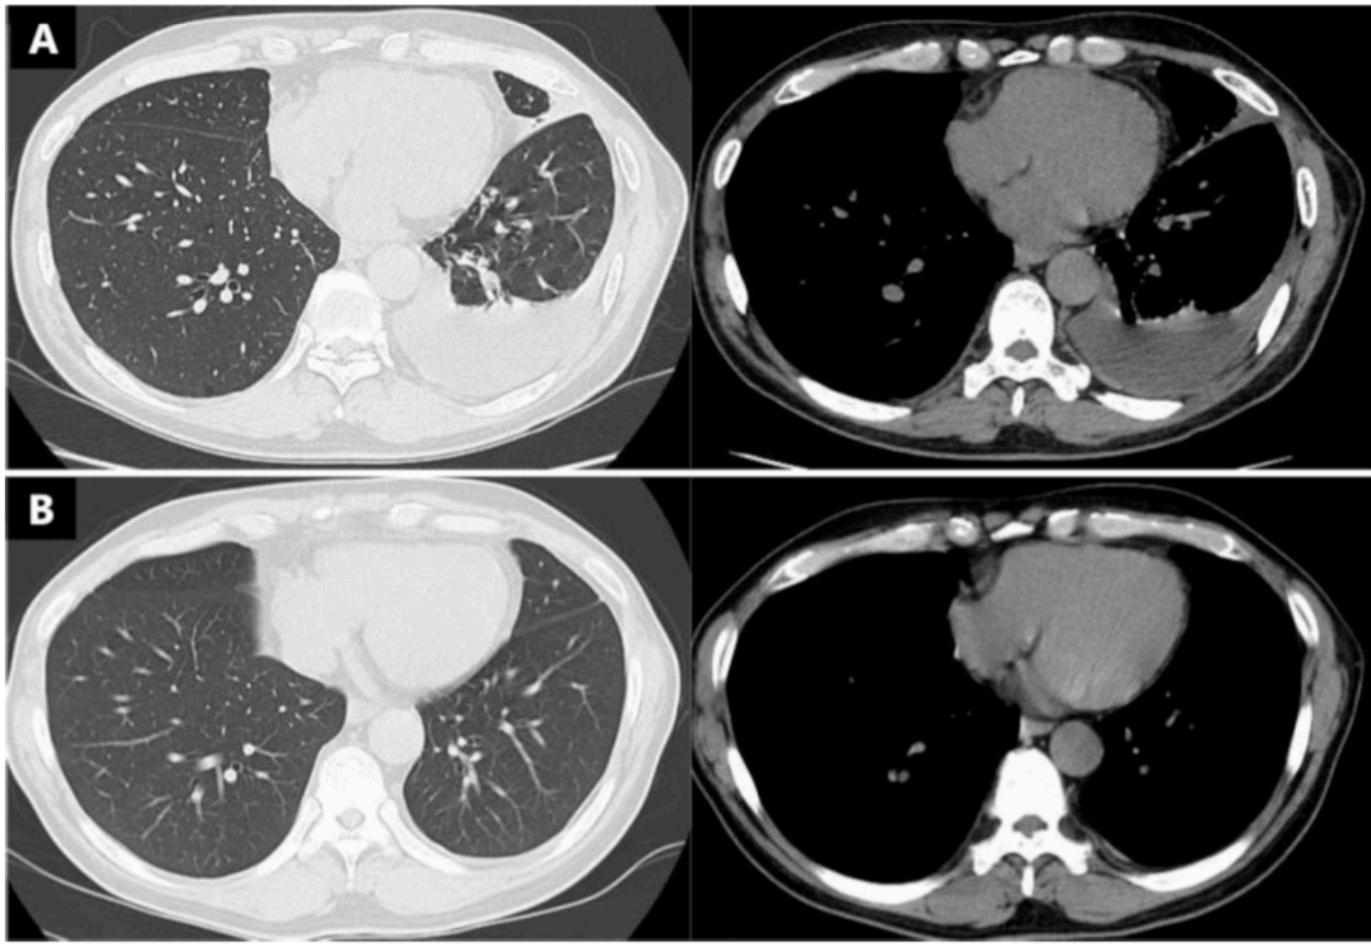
Changes in RPE observed via chest computed tomography (CT).
